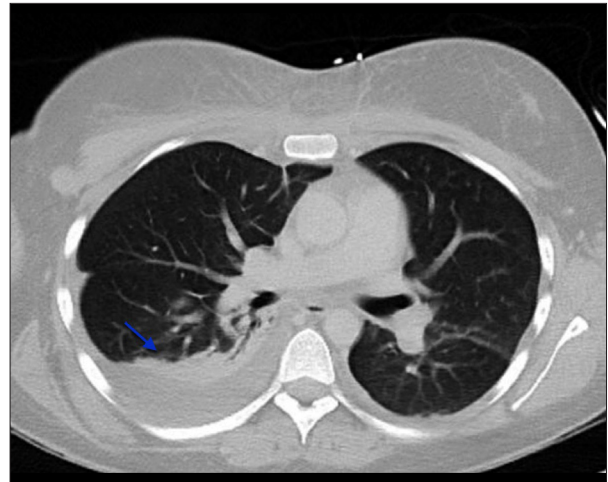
Chest CT with IV contrast reveals right basilar opacification (arrow).
